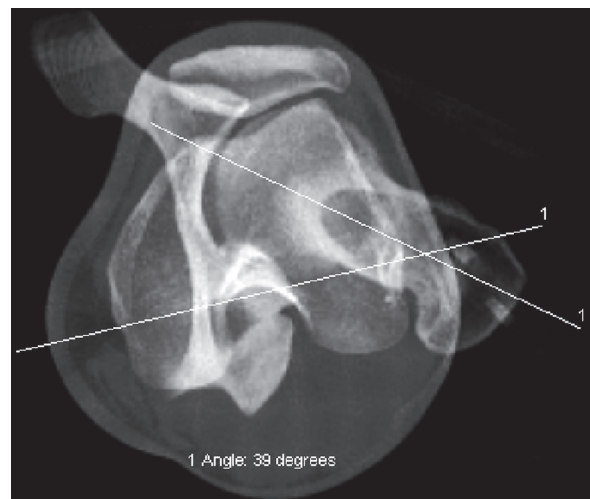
Axial CT evaluation of the femoral anteversion. The femoral anteversion is 39°
